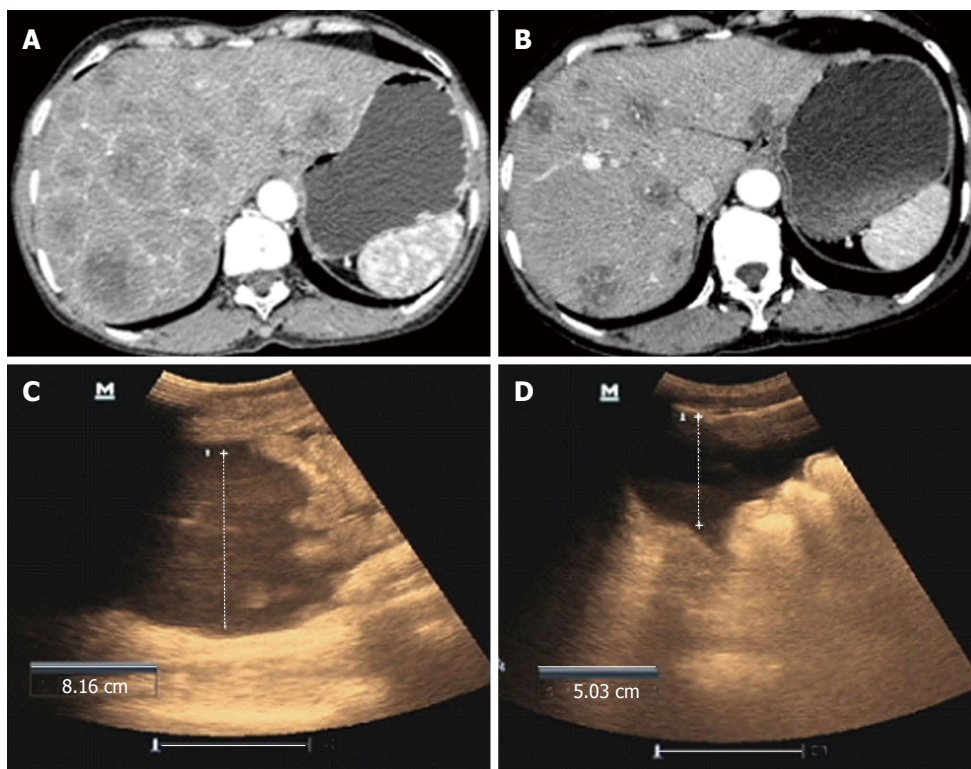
Computed tomography scan. A: Typical case 1 with hepatocellular carcinoma before treatment; B: Typical case 1 with hepatocellular carcinoma after treatment; C: Typical case 2 with hepatocellular carcinoma before treatment; D: Typical case 2 with hepatocellular carcinoma after treatment.
